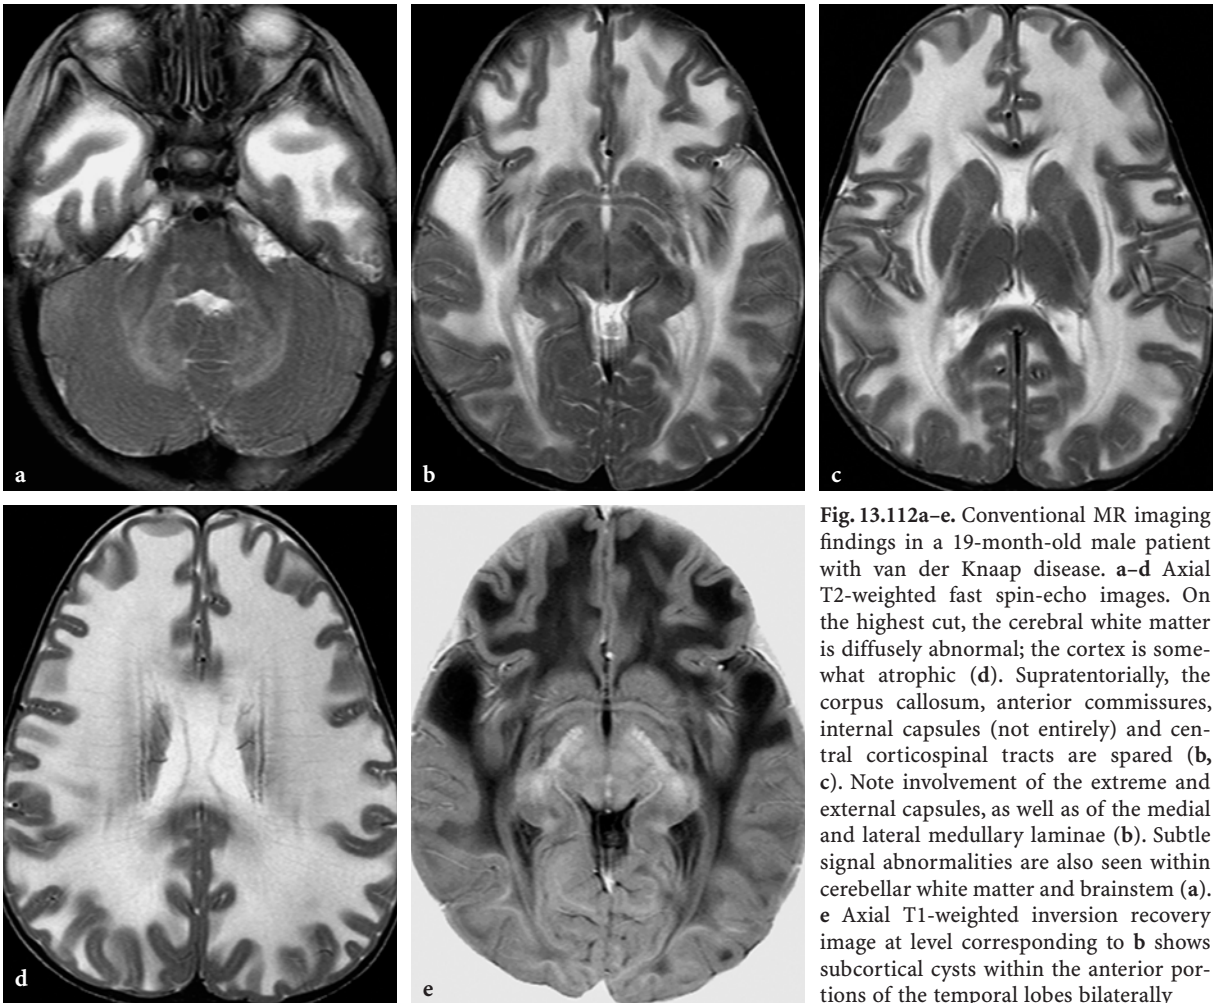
Conventional MR imaging findings in a 19-month-old male patient with van der Knaap disease. a-d Axial T2-weighted fast spin-echo images. On the highest cut, the cerebral white matter is diffusely abnormal; the cortex is somewhat atrophic (d). Supratentorially, the corpus callosum, anterior commissures, internal capsules (not entirely) and central corticospinal tracts are spared (b, c). Note involvement of the extreme and external capsules, as well as of the medial and lateral medullary laminae (b). Subtle signal abnormalities are also seen within cerebellar white matter and brainstem (a). e Axial T1-weighted inversion recovery image at level corresponding to b shows subcortical cysts within the anterior portions of the temporal lobes bilaterally
